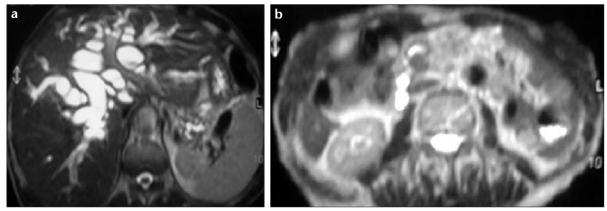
a, b. Axial heavily T2-weighted MR image at the level of the portal hilus shows dilation of the intrahepatic biliary tree and the common bile duct (a). Axial T2-weighted MR image shows a 1-cm hypointense nodular mass arising from the posterior wall of the distal common bile duct and protruding into the lumen (b).
